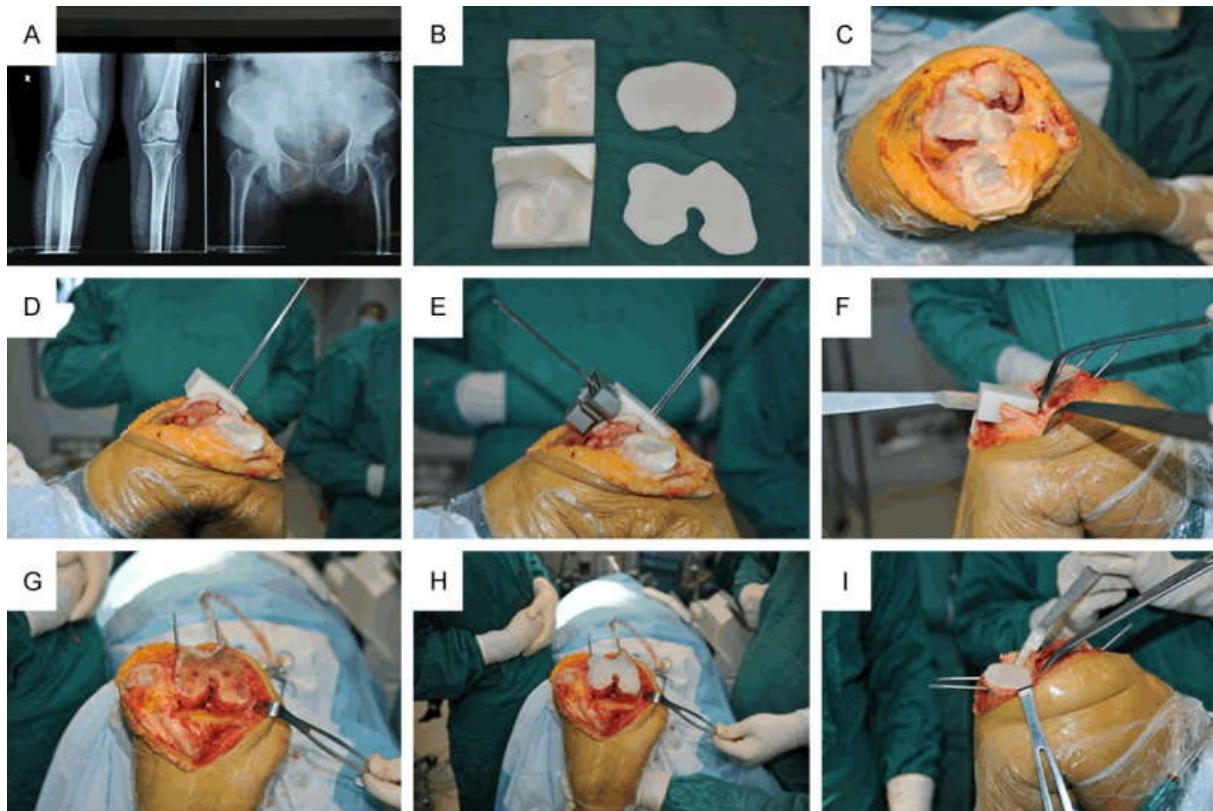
Total knee arthroplasty. A – anteroposterior radiographs of bilateral knees and hips; B – femoral and tibial components; C- incision to open the knee joint; D- attachment of jig to femur; E – femoral cuts and resection of bone; F – attachment of tibial jig; G – tibial cut and resection of bone; H – implantation of femoral component; I – implantation of tibial component [53]
